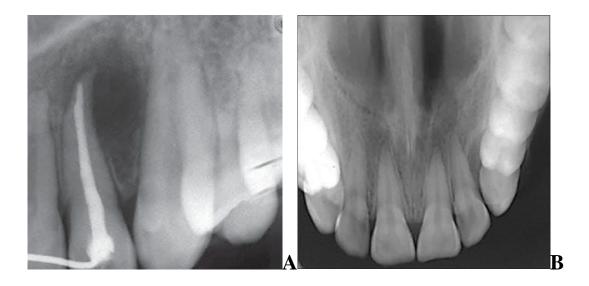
An Occlusal radiograph showing "inverted pear-shaped radiolucency". (Haring et al, 2006) B- Occlusal radiograph showing expansion of labial cortical plate. (Reddy et al, 2017)
